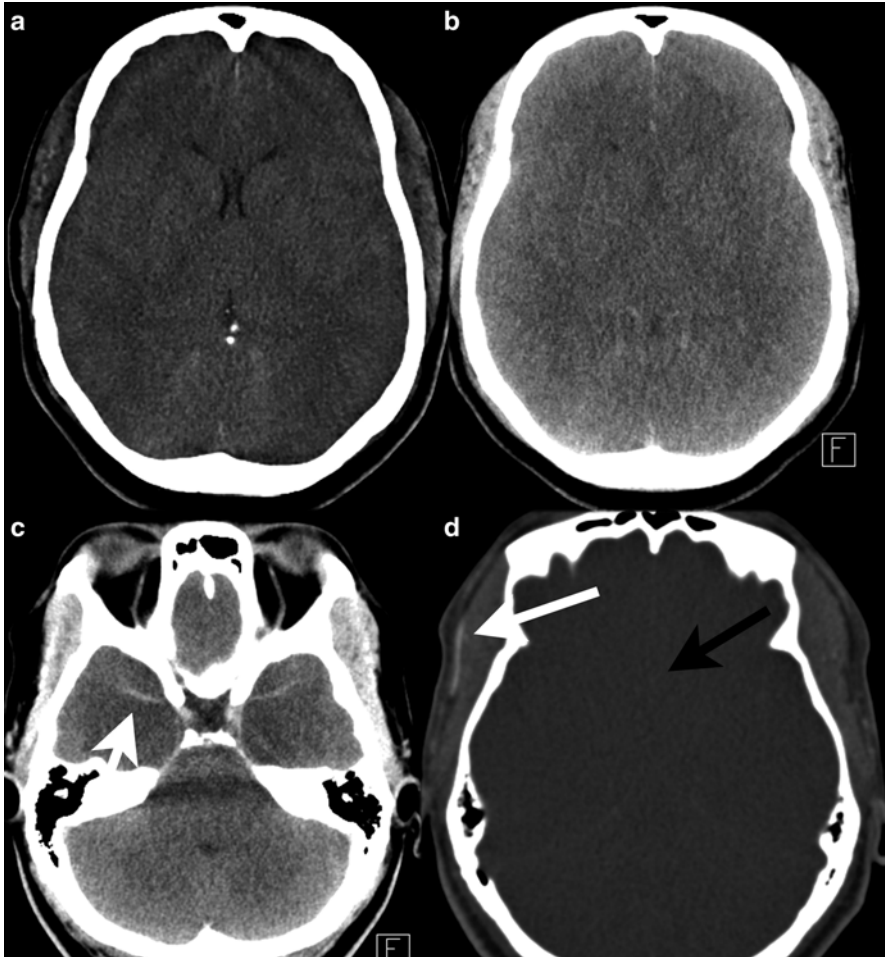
Patient presented comatose with severe hyponatremia. Initial CT on day 1 (a) shows mass effect on the ventricles with spared gray-white matter differentiation. On day 2 (b) there is loss of differentiation, with severe hypodensity of the brain parenchyma, with visible left and right middle cerebral artery. The vessels appear relatively dense (c, *white arrow*), resembling enhancement of vessels, but this is due to the surrounding hypodensity of the brain parenchyma. This phenomenon is called a pseudo-subarachnoid hemorrhage sign. The next day 2-phase CTA was performed and demonstrates enhancement of the extracranial vessels (*white arrow*), while the intracranial arteries are not enhancing (d, *black arrow*). Cerebral circulation arrest was concluded
